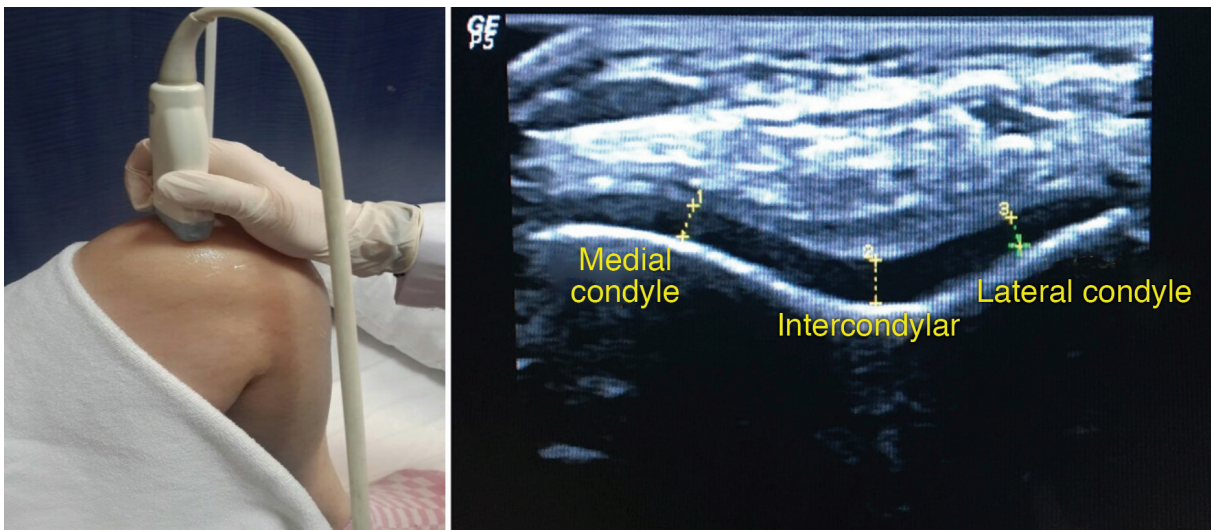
Positioning the ultrasonographic probe in axial plan and imaging the cartilage in 3 points
